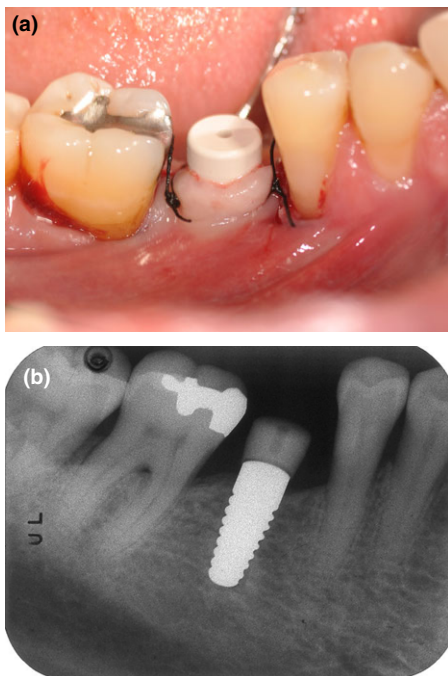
(a, b) Photograph and radiograph of one case on day of surgery.
